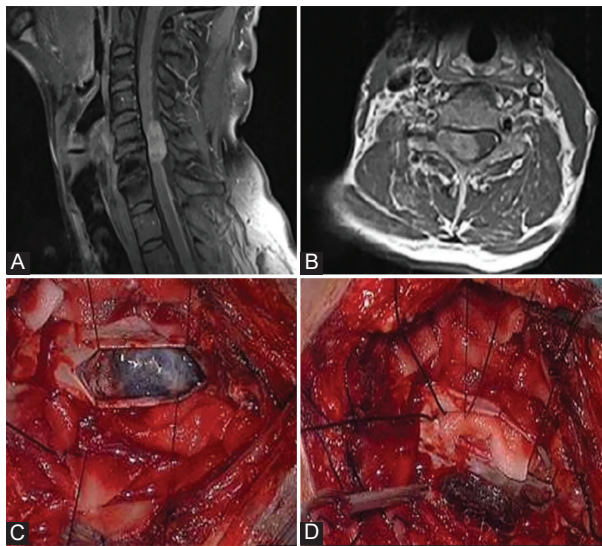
Primary extracutaneous melanoma. (A) Lateral view of the primary melanoma at the level of C5/C6, showcasing the tumor's location and extent. (B) Magnetic resonance imaging showing the intradural extramedullary localization of the melanoma, providing radiological insight. (C) Intraoperative image showing the darkly pigmented neoplastic mass, visually confirming melanoma. (D) Post-surgical intraoperative image.
